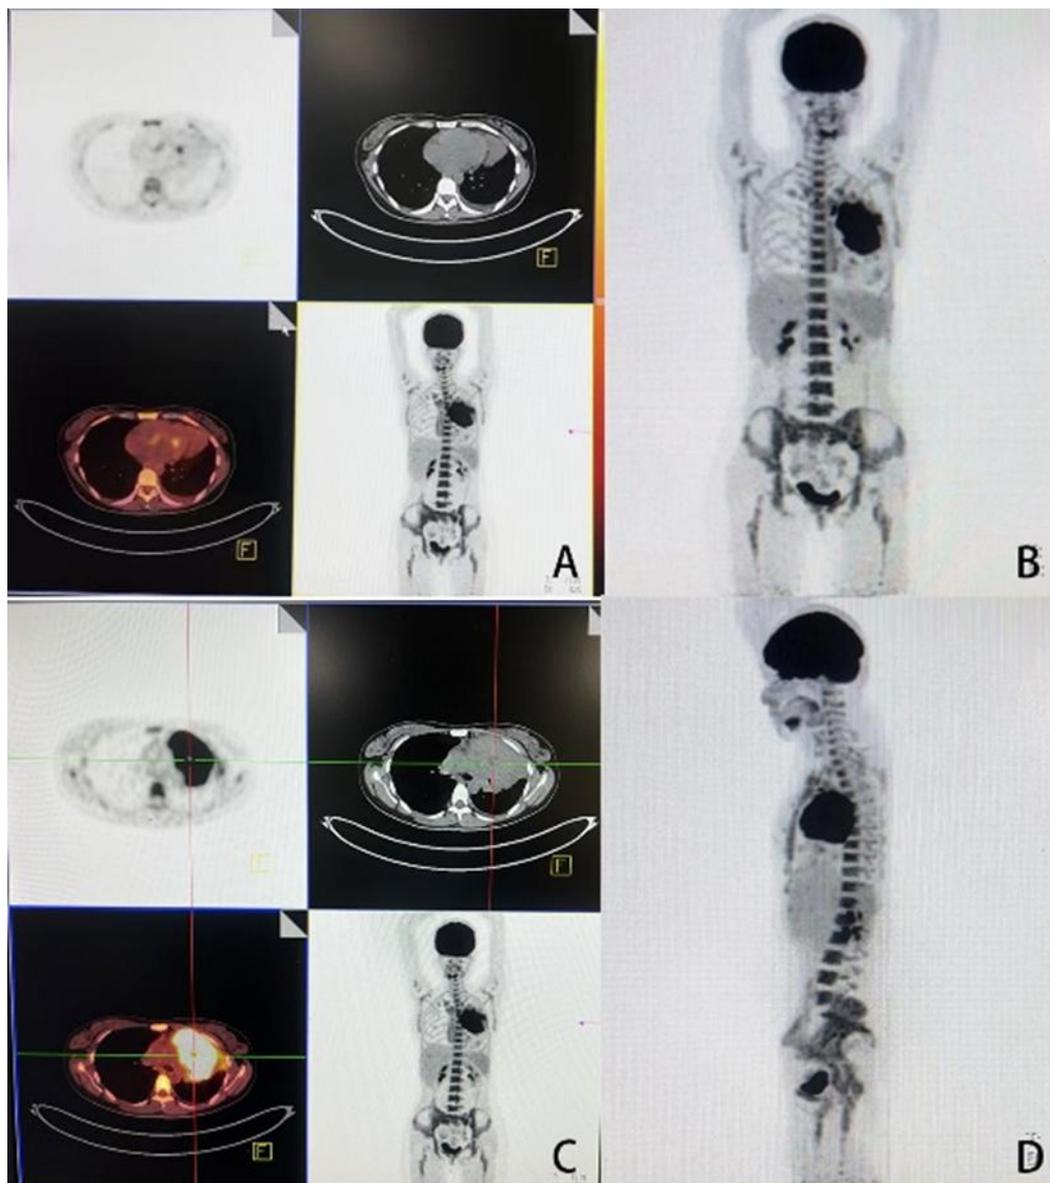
The anterior segment of the left upper lobe and the lingual bronchus are not visualized, and the anterior segment and the lingual segment of the lung tissue show a solid mass shadow; low-density lesions are seen in the central area; still, the possibility of benign lesions is considered high, and the possibility of internal focal tumors cannot be completely ruled out (A); Bilateral posterior mandibular angle, axillary inflammatory lymph nodes, and the lymph nodes adjacent to the aortic arch (B); The inflammatory lesion in the posterior segment of the left upper lobe with left pleural effusion (C); and hemangiomas may appear in the 4th, sixth, and seventh cervical vertebrae and the 3rd, fourth, and fifth thoracic pyramids the; right femoral neck, right ischial tuberosity bone island shadow(D); Abnormally active FDG metabolism in the bone marrow cavity of the whole body (A, D).
